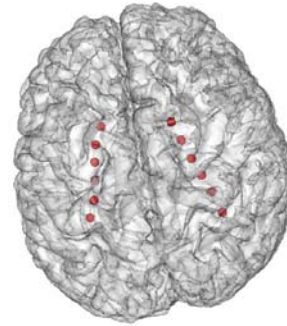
3D visualization of deep MRI-compatible electrodes (red balls).
